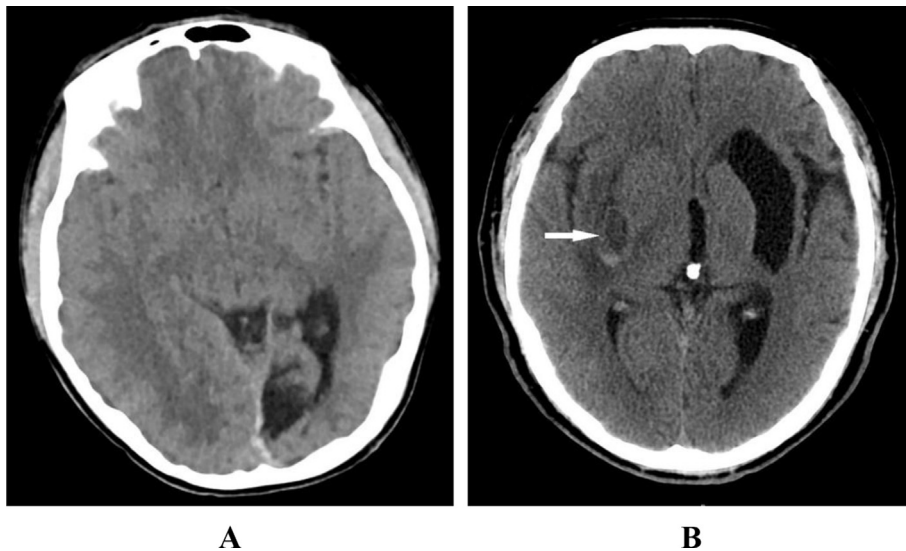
(A) A 15-year-old boy with cerebral paragonimiasis. Plain CT scan of brain shows patchy low density in the left occipital lobe. (B) A 38-year-old man with cerebral paragonimiasis. Plain CT scan of brain shows patchy mixed density in the right basal ganglia (arrow) and kidney-shaped low density area in the left basal ganglia.
